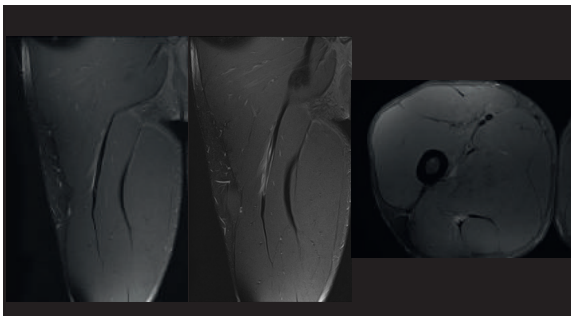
(Case #3). MTJ strain of the central tendon of the long head of the biceps femoris muscle. As MRI signs, we find cicatricial changes in the central tendon, with peritendinous oedema, tendinous mixed disruption, minimal intermuscular fluid/haemorrhage, and a very slight loss of tension in the biceps tendon.
